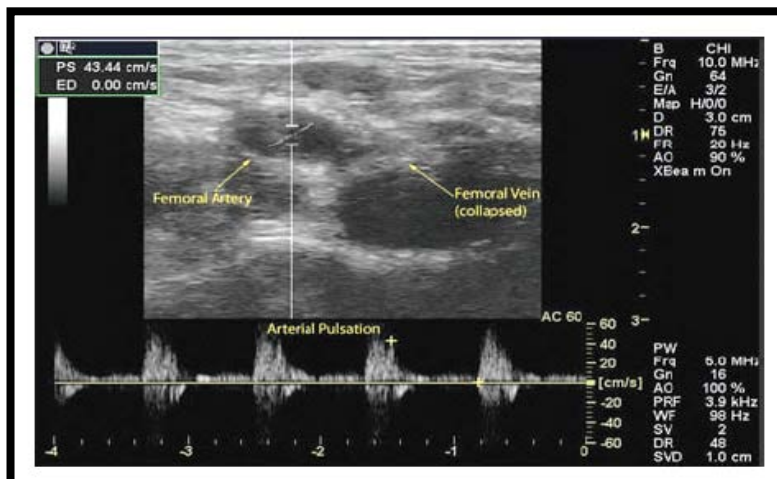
Pulse-wave Doppler showing arterial flow in the femoral artery (Otto, 2000)
